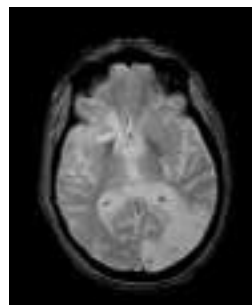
C) GRE gradient Echo MRI sequence showing high signal intensity at left occipital area.
